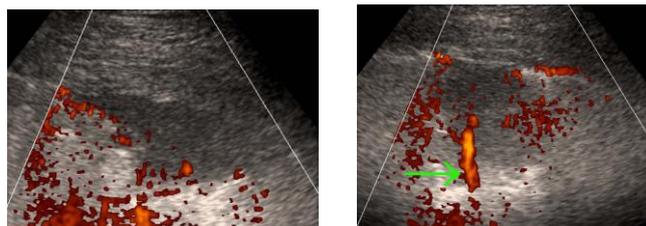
Power Doppler ultrasonography
